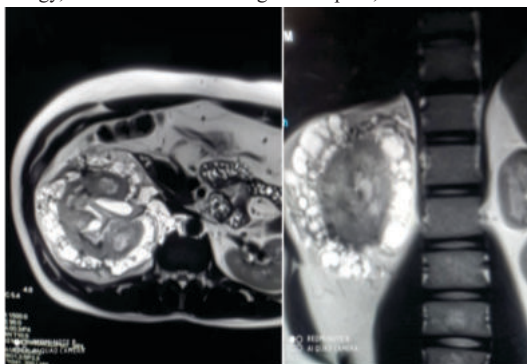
MRI KUB views of Right Renal Lymphangiomatosis
